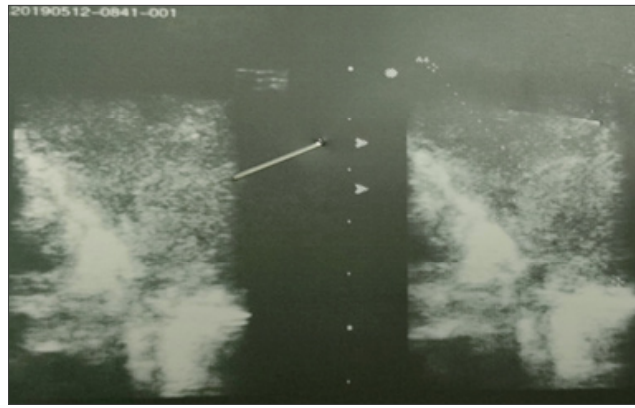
Ultrasound aspect of the testicle showing multiple solid scrotal tumor formations infiltrating the vaginal tunics (Photo credit Dr Sarah ZEROUAL)*
